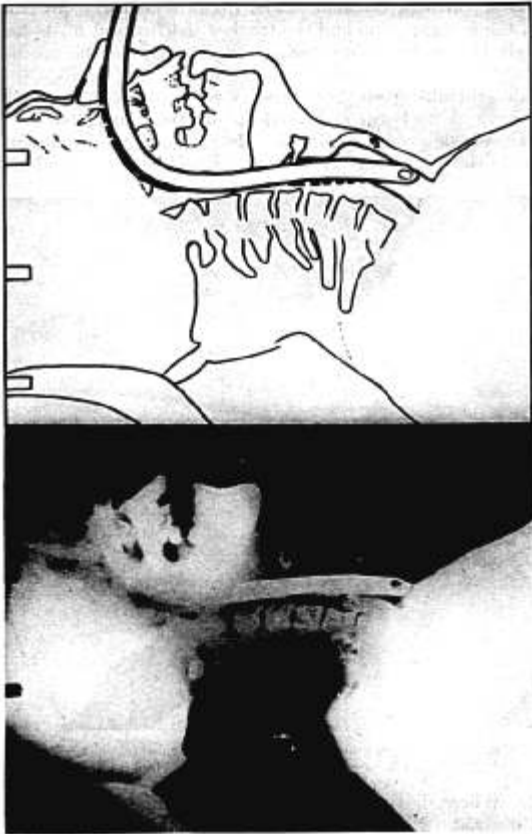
Roentgenogram of nasal Magill tube in place. The tip of the tube is deformed by the pressure on the anterior tracheal wall. The posterior commissure is compressed.
